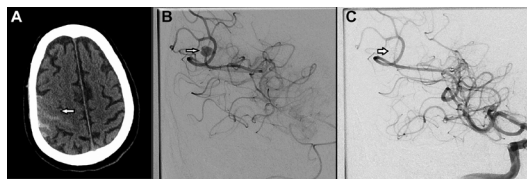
(A) Head CT. New subarachnoid haemorrhage in the posterior right sylvian fissure and right parietal and right frontal region. (B) Cerebral angiography. An irregularly contoured fusiform distal right MCA mycotic aneurysm before the embolisation (arrow). (C) Successful Onyx embolisation of the distal right MCA mycotic aneurysm and the parent vessel sacrifice (arrow).
